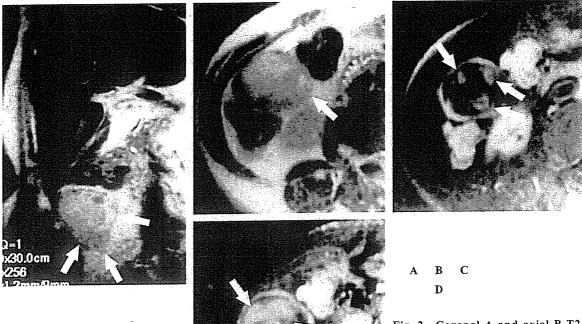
Coronal A and axial B T2-weighted MR images show a moderately hyperintense and heterogeneous mass (arrows) arising from the posterior inferior segment. On post-gadolinium MR images, tumor shows nodular enhancement (arrows) on early phase C, and progressive enhancement on delayed phase D.
